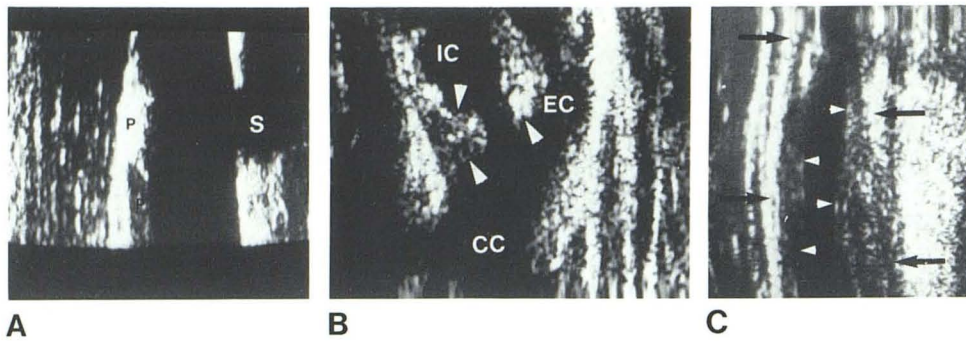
Differing sonographic appearance of atheromatous plaque. A, Long flat plaque (P) on superficial wall of vessel has highly echogenic distal extent. Deep surface of vessel at this level and adjacent structures not imaged because calcification in plaque causes acoustical shadowing (S). B, Plaque of intermediate echogenicity at origin of internal carotid (IC) (arrowheads) produces stricture at mouth of vessel. External (EC) and common (CC) carotid arteries. C, Long flat plaque of relatively low echogenicity on both superficial and deep walls of common carotid. Outer margins of vessel (arrows) and narrowed residual lumen (arrowheads).
